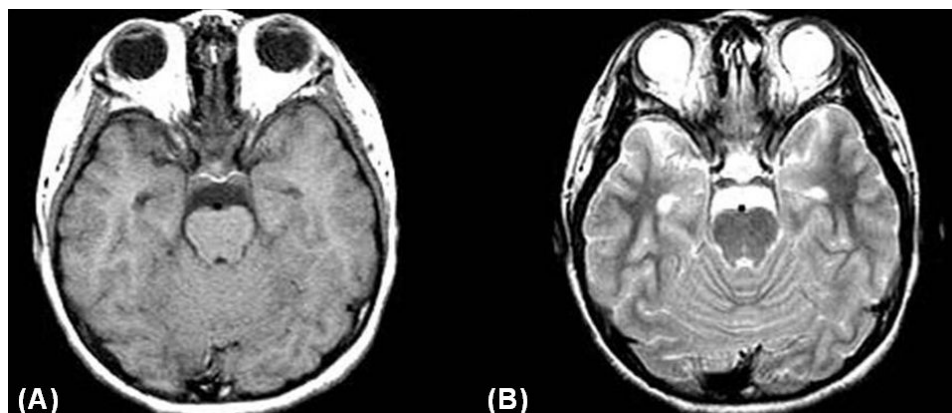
Brain magnetic resonance imaging scan obtained on day 2 shows no abnormal intracranial findings in T1 (A) and T2 (B) weighted images.
